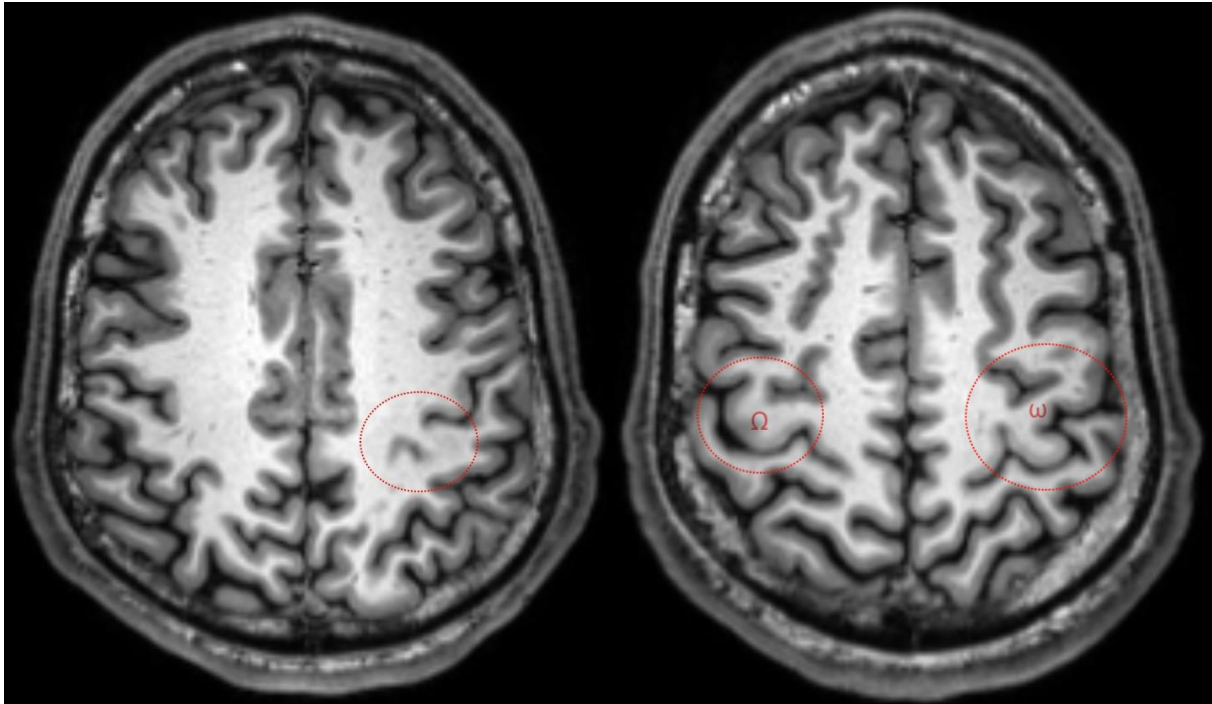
Axial magnetic resonance imaging (MRI) scan of a healthy subject's brain. Left: pli-de-passage fronto-pariétal de moyen marked in red. Right: Both hemispheres' omega-shaped hand knobs marked in red. Note that the hand knob can resemble both an uppercase “Ω” or a lowercase “ω”
